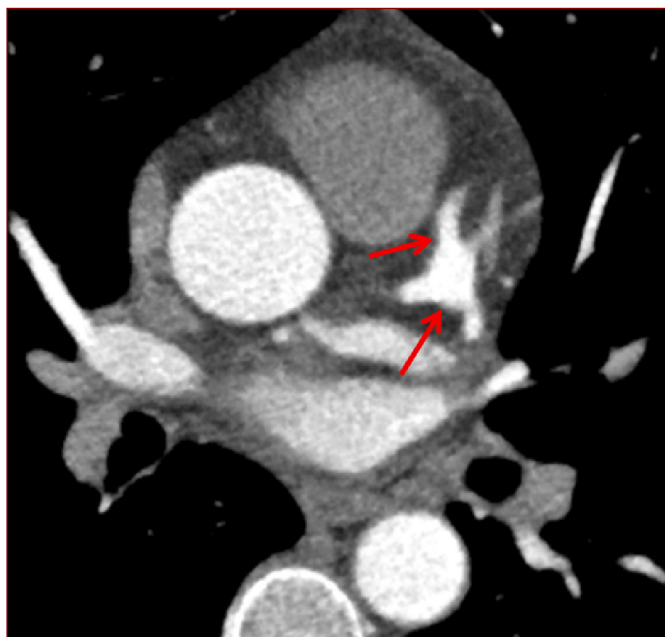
Coronary computed tomographic angiography image. Arrows indicate the aneurysm distal to the left main coronary artery and proximal to the left anterior descending artery.
